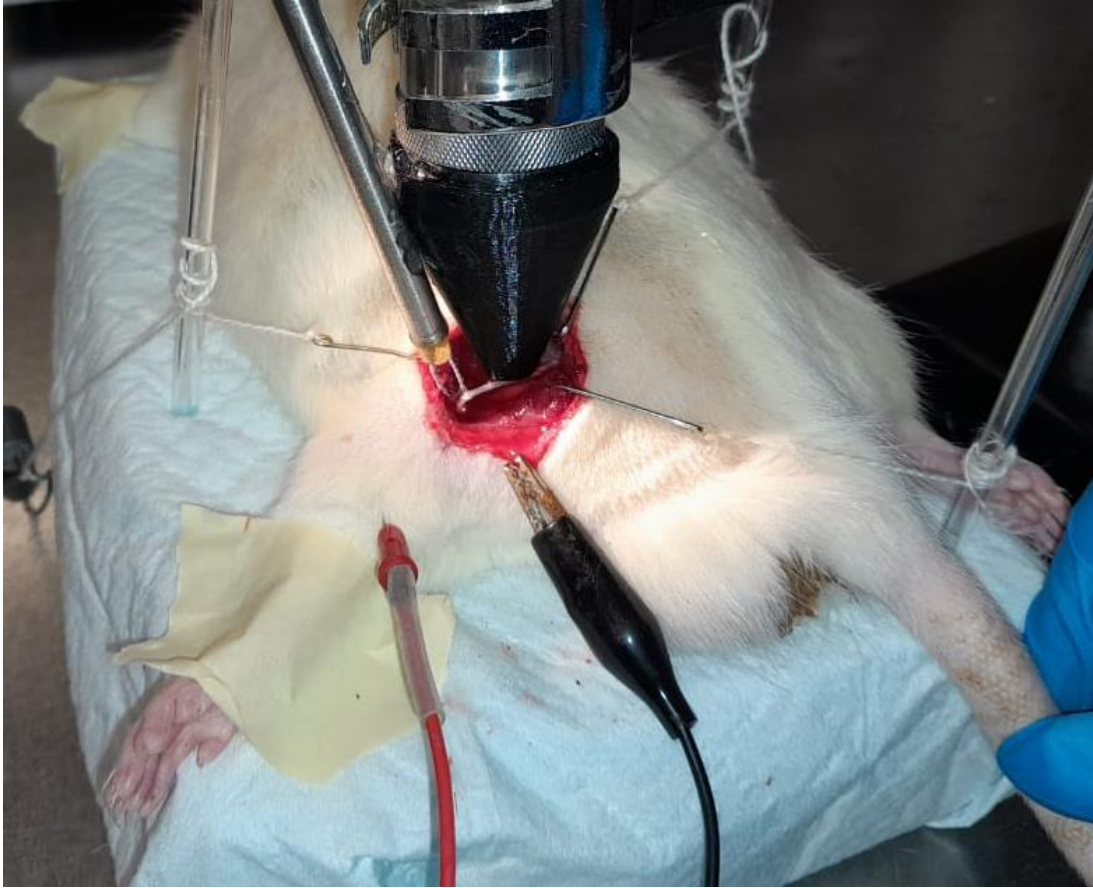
Photo of experimental setup. The stimulating electrode is hooked to the exposed sciatic nerve. The transducer is coupled with cone filled with ultrasound gel that serves as a medium for propagation.
